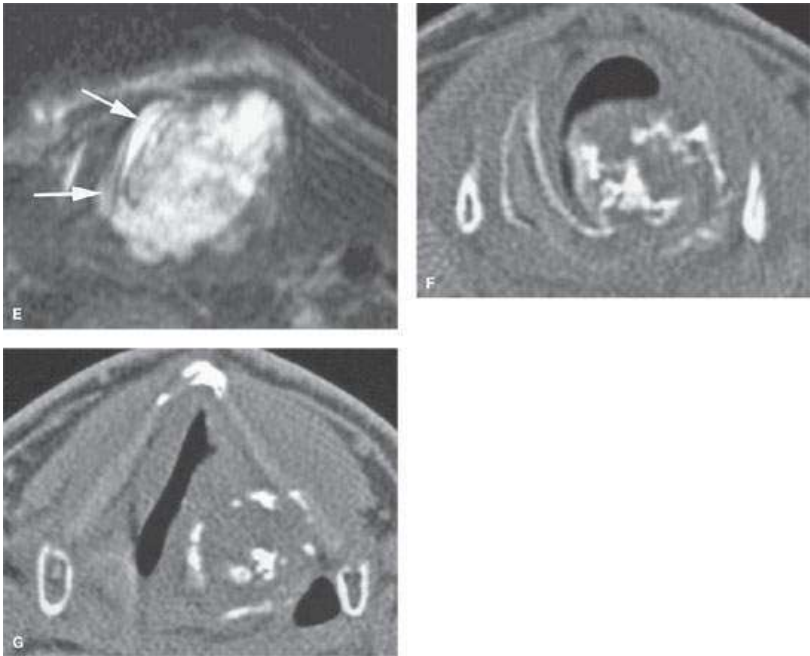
Two patients with laryngeal chondrosarcoma. A–E: Patient 1, CT and MR images of the chondrosarcoma arising from the cricoid cartilage. A, B: Bone and soft tissue views respectively showing the extent of the soft tissue mass and matrix calcification involving predominantly the left side of the cricoid cartilage. C: T1W non contrast image showing the tumor matrix to be lower in signal intensity than muscle. D: CE T1W image showing predominately peripheral enhancement of the tumor and a large central portion that is non-enhancing. E: T2W image somewhat degraded by motion artifact showing the tumor to be of generally bright signal intensity so that it cannot be differentiated from the fat within the normal right cricoid arch (arrows). F, G: Patient 2 CT study showing a laryngeal chondrosarcoma with a more typically calcified chondroid matrix than in Patient 1 extending the aryepiglottic fold in (G).
